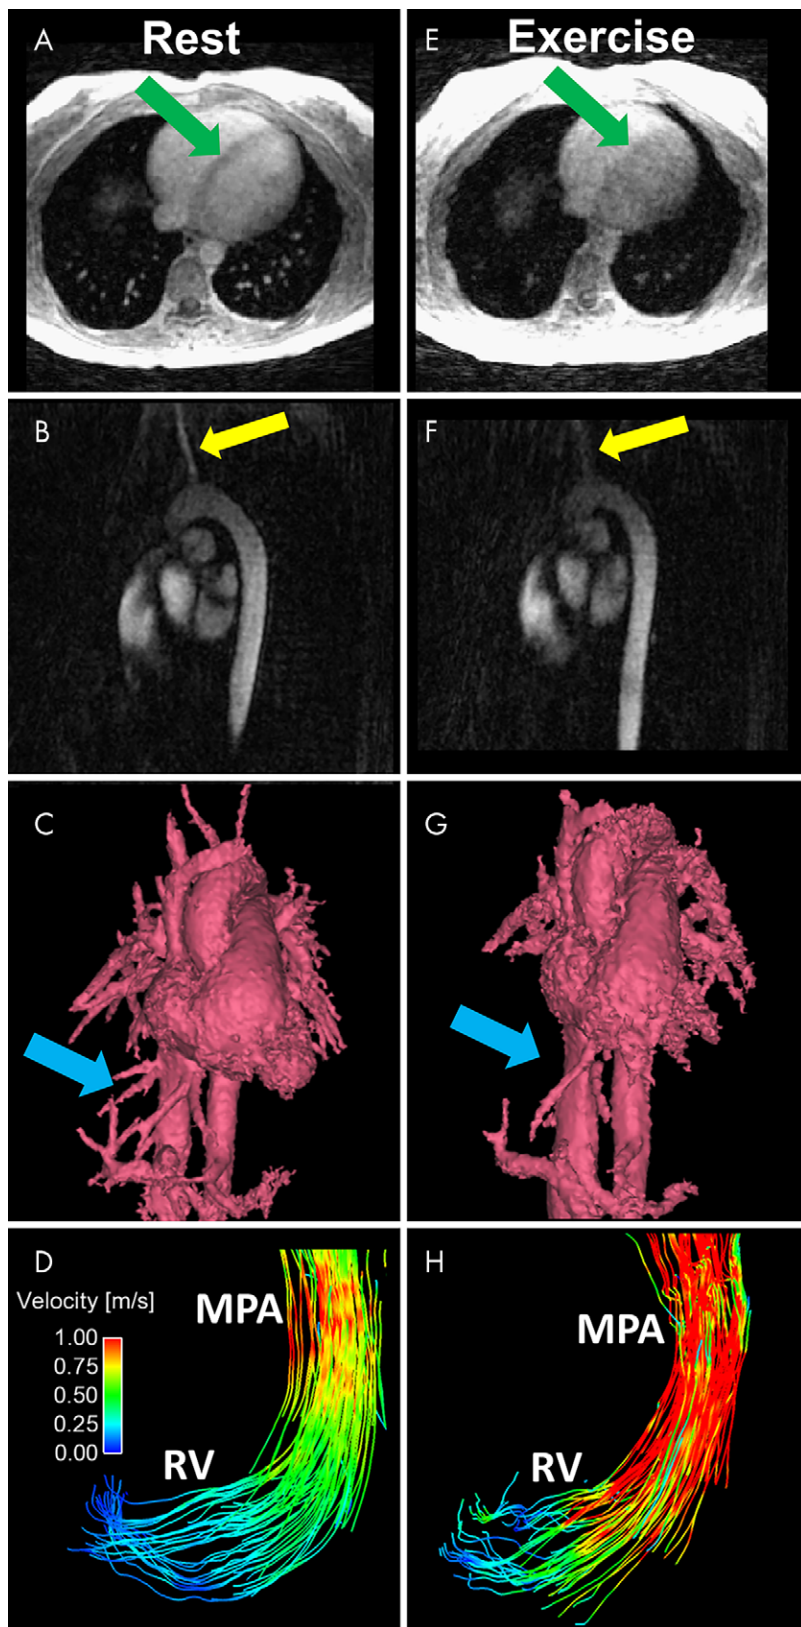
A–D, Representative images obtained at rest include an A, axial magnitude image, B, sagittal PC angiogram, C, segmented volume-rendered PC angiogram reconstructed from a 4D flow MRI acquisition, and D, pathline visualization image in the RV and MPA. Images E–H show corresponding images obtained during exercise. Increased blurring and decreased conspicuity of regions with slow or complex flow are observed in the axial magnitude image (E, green arrows) and sagittal PC angiogram (F, yellow arrows). G, The volume-rendered angiogram obtained during exercise shows loss of fine vessel detail (blue arrows). H, The pathline visualization image shows increased velocities in the RV and MPA at peak systole. MPA = main pulmonary artery, PC = phase-contrast, RV = right ventricle.
